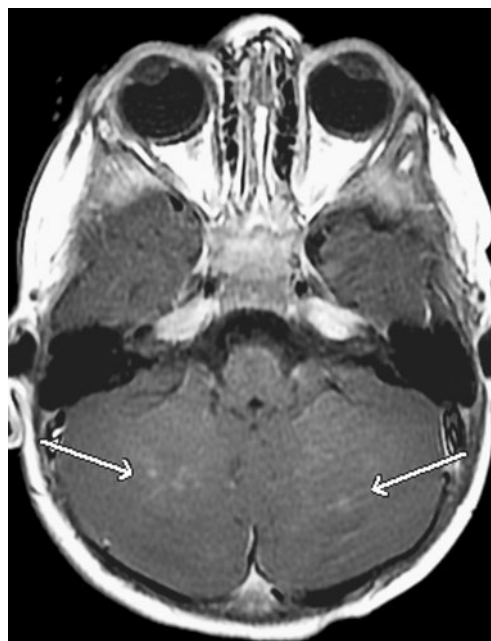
Axial T1-W post-gadolinium MR image demonstrates punctate enhancement within the cerebellum (arrows)
